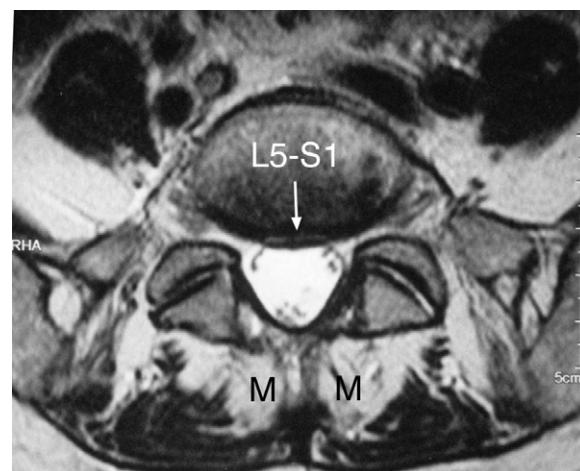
MRI axial T2-weighted image at the L5–S1 level showing the shallow focal posterior annular bulge (arrow). M = multifidus muscle with fibro-fatty replacement of part of the muscle.
